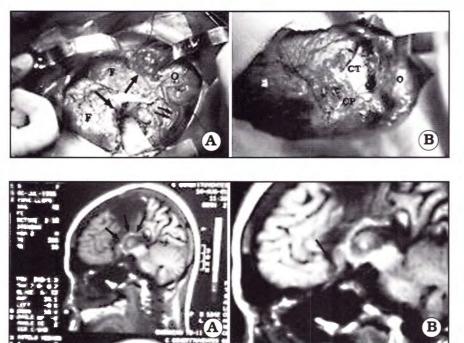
A. Central area resection (thin arrow) and temporal lobe disconnection (thick arrow) from behind the insula are observed. F: frontal lobe; T: temporal lobe; O: occipital lobe. Two arrows: arterialized vein. B. F: frontal lobe; T: temporal lobe; CP: choroidal plexus; CT: cerebellar tentorium. The arrow shows the posterior disconnection of the temporal lobe.
